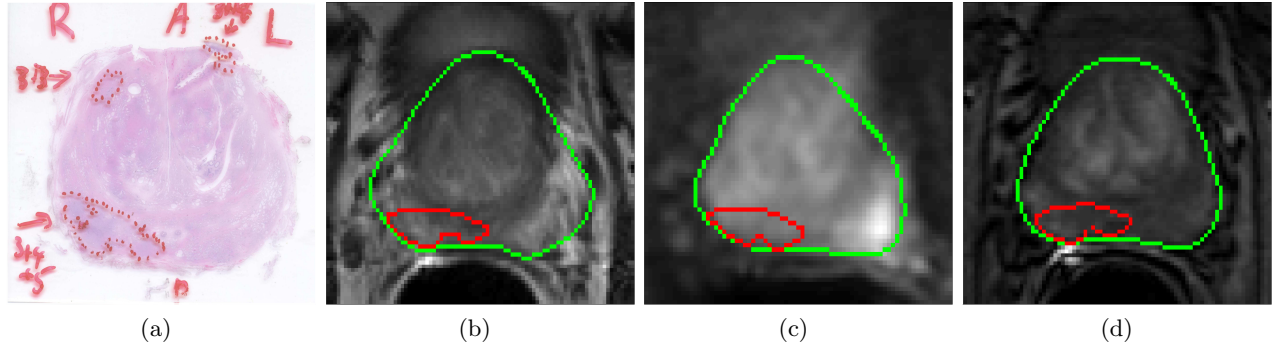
(a) Peripheral zone tumor of Gleason Grade (3+4+5) from pathology slide is mapped to the corresponding (b) T2-weighted, (c) DTI and (d) DCE-MRI slice. The green contour represents the boundary of the prostate gland and the red contour is the mapped tumor.
